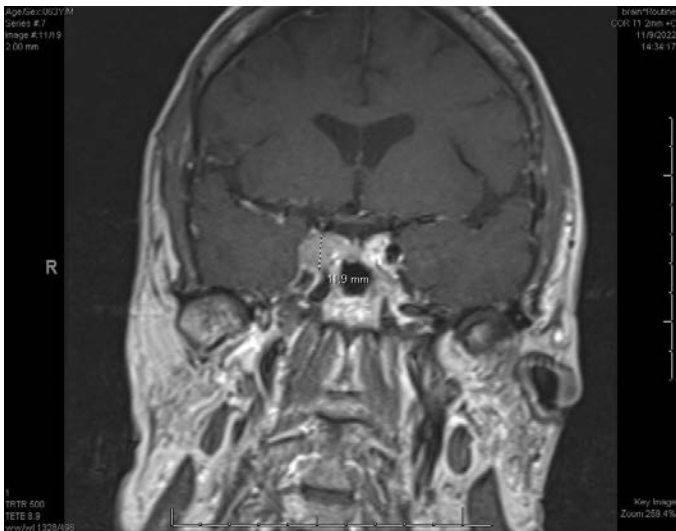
MRI Pituitary with contrast. 1.0 x 1.7 x 1.2 cm mass involving the right cavernous sinus and the right sella turcica. Considerations may include lymphoma/PTLD given the concurrent abdominal findings, versus other lesions in this region such as a pituitary adenoma or meningioma.
